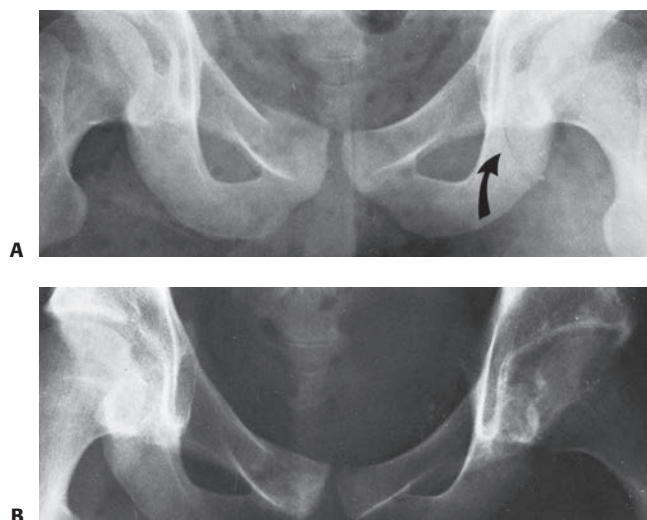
A: Nondisplaced fracture (*curved arrow*) through left ischium and contralateral pubic ramus fracture. B: Follow-up radiograph shows mild displacement and incongruity of the acetabulum and complete healing of the superior pubic ramus fracture. Either displacement of the fracture fragments or premature closure of the triradiate cartilage could have contributed to the incongruity of the femoral head in the acetabulum.
